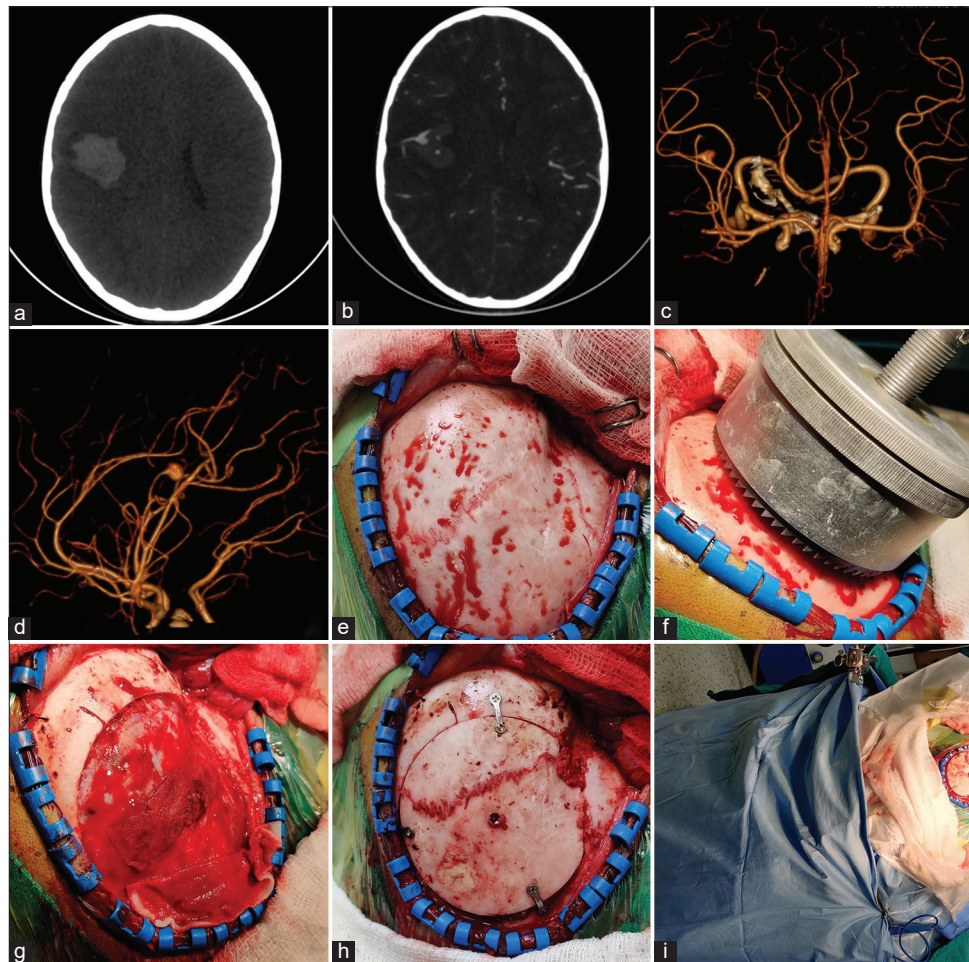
NCCT head shows subarachnoid hemorrhage with intracerebral hemorrhage in the right posterior frontal lobe (a), M3 middle cerebral artery aneurysm seen on CT angiography (b-d), intraoperative FST exposure with trepan (e and f), status post craniotomy (g), bone flap fixed using plates and screws (h), and operative field neat and clean during entire procedure (i).
